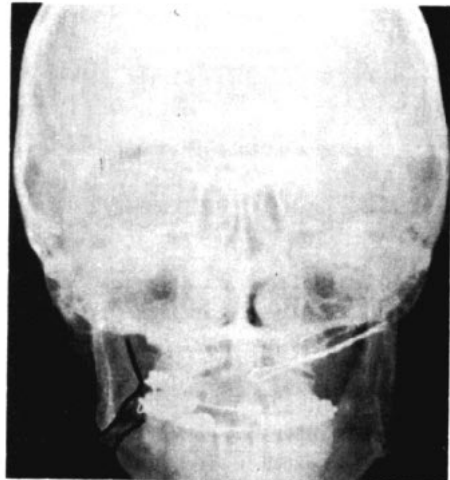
Photograph of x-ray taken at the start of reduction.
